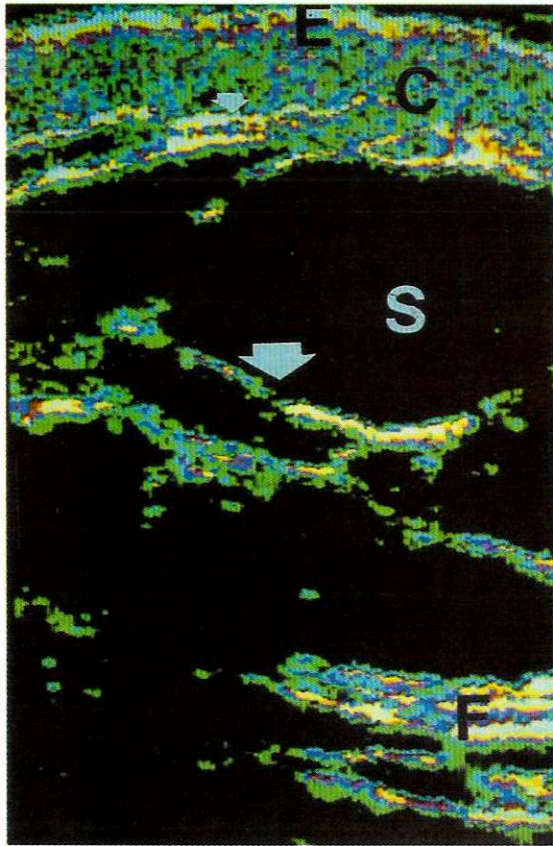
Ultrasound B-scan of a sclerotic plaque in the groin (Case Study 5) (E: entry echo; C: corium; S: subcutaneous fatty tissue; F: inguinal ligament; small white arrow: enhanced reflexes; large white arrow: hyperechoic bands of connective tissue).
